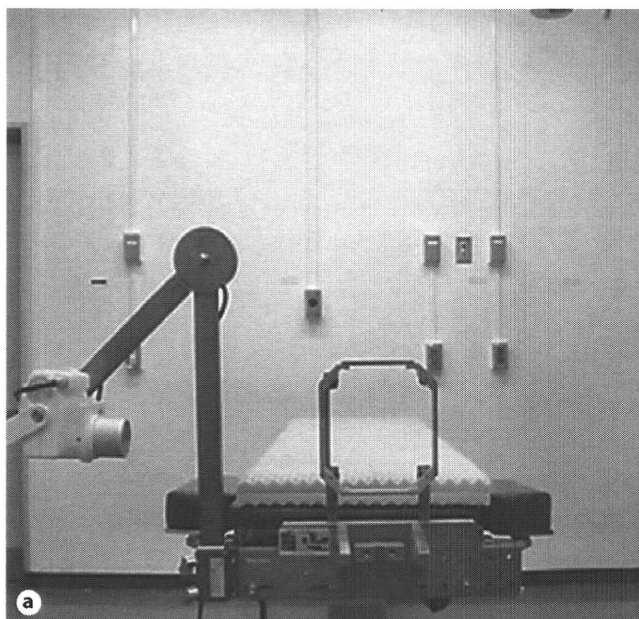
The stereotactic X-ray system used in this study consisted of a movable X-ray camera with a crossbar and was adopted to be always parallel to the frame with the X-ray film cassette. a Stereotactic X-ray system for the evaluation from lateral projection. b Lower setting from anterior-posterior projections.
